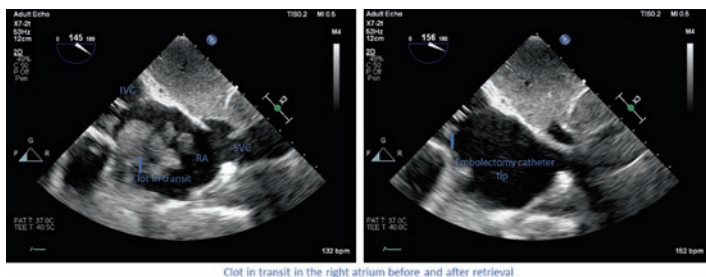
Transthoracic Echocardiogram showing a clot in transit. The clot extends from the IVC into the right atrium across the tricuspid valve and into the right ventricle
